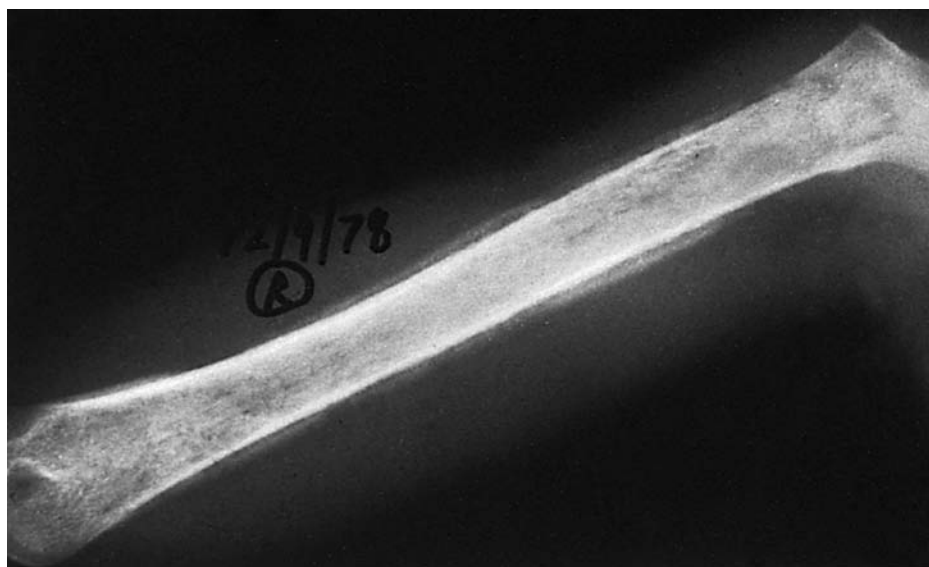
Radiograph showing lytic lesions and periosteal elevation with osteomyelitis.
